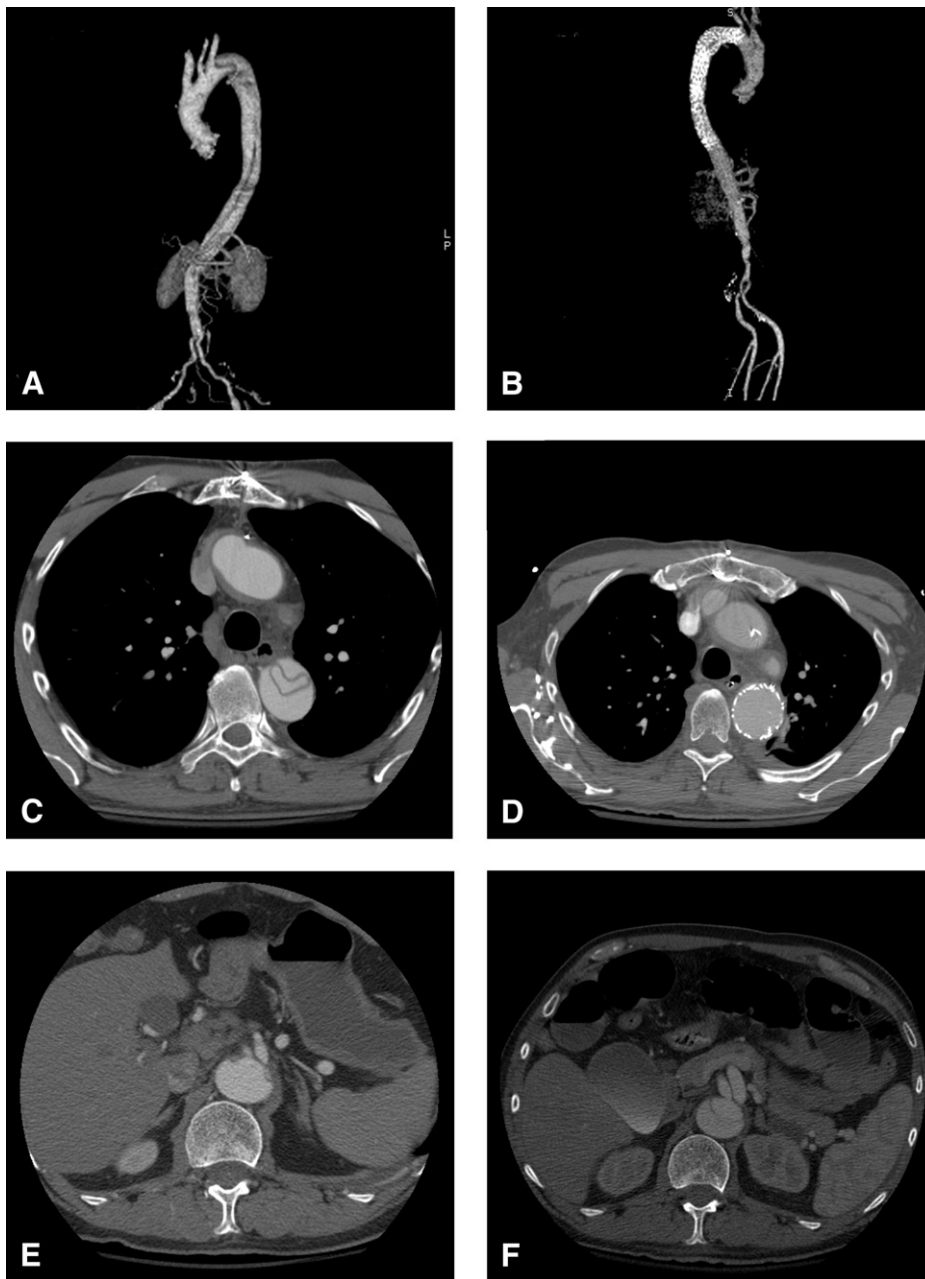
Computed tomography angiogram of the aorta. A, Three-dimensional reconstruction of acute aortic dissection shows compressed true lumen. B, Three-dimensional reconstruction shows dissection after placement of endograft. C, Axial image of dissection shows compressed true lumen that is completely detached from the surrounding adventitia. D, Axial image of thoracic aorta in same patient after endografting shows expansion of the true lumen with no flow in the false lumen. E, Axial image shows the celiac axis with compressed true lumen. F, Axial image shows the celiac axis in same patient after placement of proximal endograft. The true lumen has now expanded.
